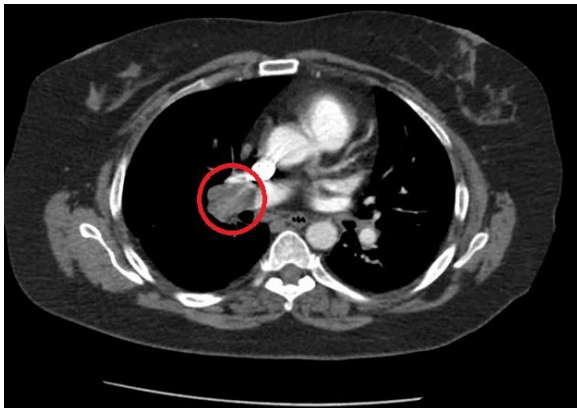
A CTA of the chest demonstrates an embolus in the right main pulmonary artery which appears slightly dilated (red circle).
